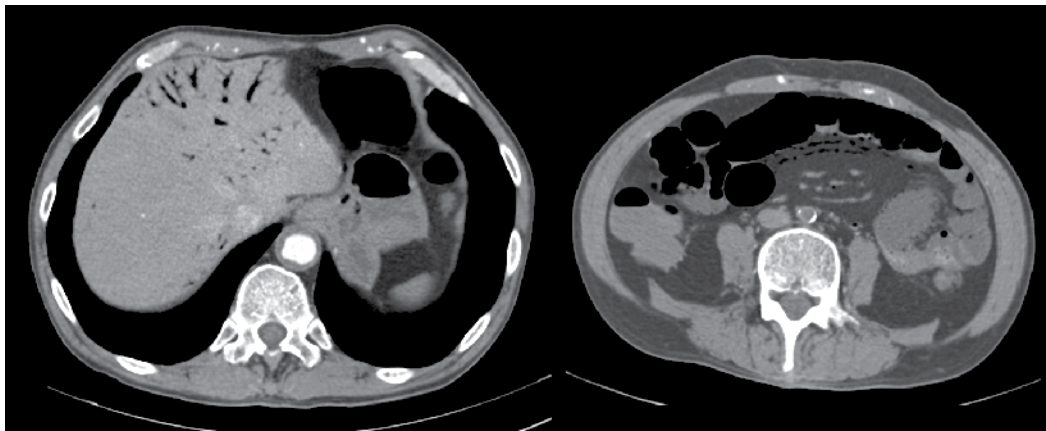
Abdominal CT scan of a patient who developed peritonitis several days after undergoing coronary artery bypass grafting. The study shows diffuse portal venous gas (left) and pneumatosis of the bowel and the mesentery (right). The patient underwent laparotomy with segmental resection of necrotic small bowel. A planned “second-look” laparotomy showed no further bowel necrosis and primary small bowel anastomosis was performed.
